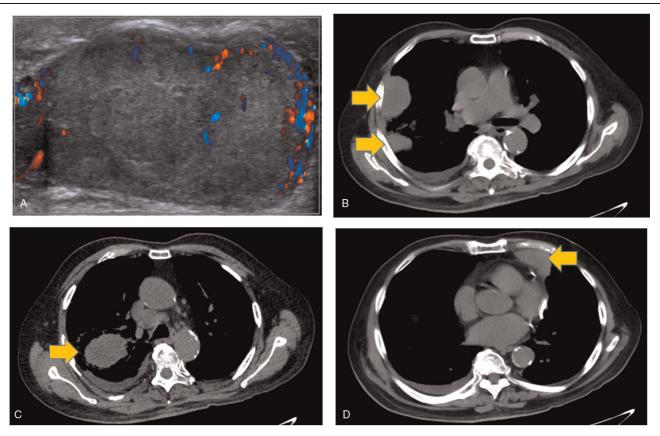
(A) Scrotal ultrasound showing an enlarged left testicle $5.1 \text{ cm} \times 2.4 \text{ cm} \times 3.1 \text{ cm}$ mostly occupied by an intratesticular mass measuring $3.8 \text{ cm} \times 1.9 \text{ cm}$ with internal vasculature; (B) chest computed tomography showing multiple bilateral large lung masses consistent with metastatic disease (arrows) including: $5.6 \text{ cm} \times 4.0 \text{ cm}$ mass in the posterior segment of the right upper lung, $5.4 \text{ cm} \times 3.5 \text{ cm}$ pleural-based mass laterally in the right middle lung; (C) $4.4 \text{ cm} \times 2.0 \text{ cm}$ mass laterally in the right lower lobe with a small right pleural effusion; (D) $4.2 \text{ cm} \times 4.1 \text{ cm}$ left upper lobe mass.
